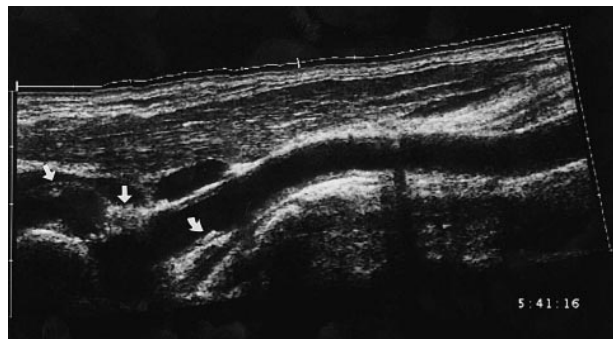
Extended-FOV sonogram shows atherosclerotic plaque at the carotid bifurcation that extended to the proximal ICA (straight arrows). The lumen was narrowed but the stenosis was less than 40%. Another small plaque was detected in the CCA (curved arrow). The normal double-line pattern was obscured at these sites of disease, and there was diffuse intimal hyperplasia at the CCA.
